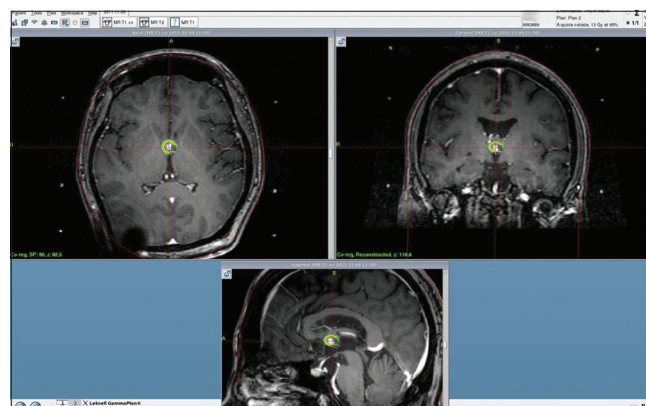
Gammaknife plan summary showing axial, coronal and sagittal T1 weighted with contrast MRI views. 13 Gy at 65% was prescribed
